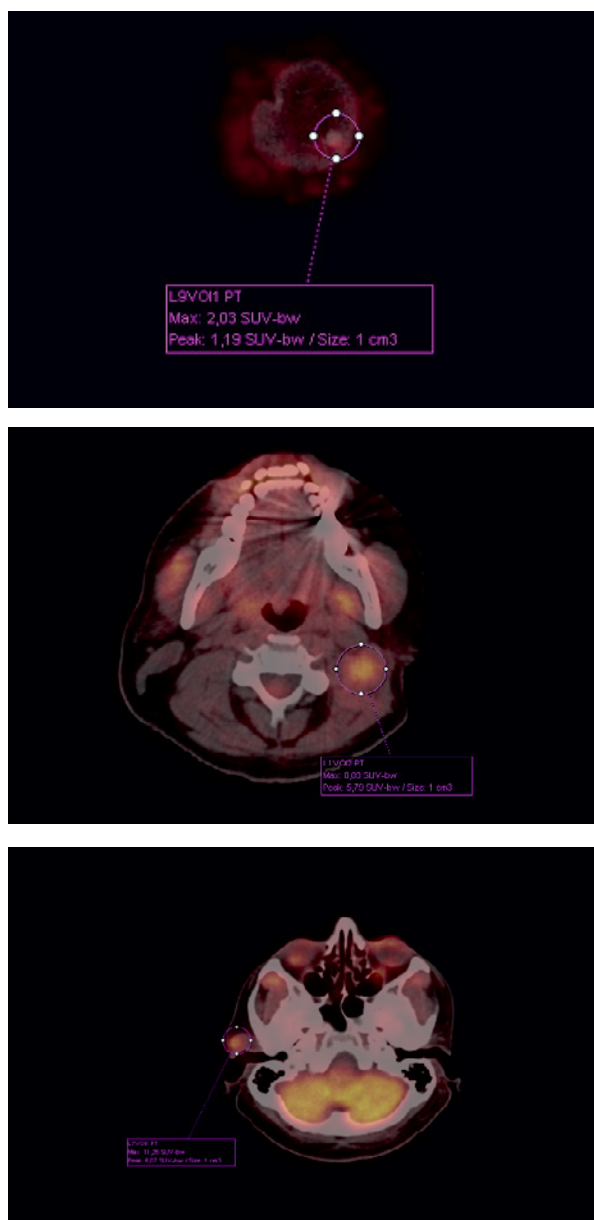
PET-CT — February 2017
